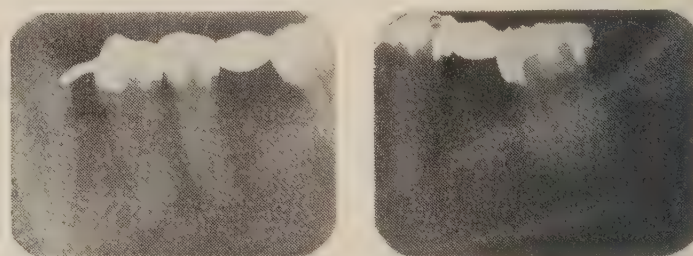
Radiographs taken in October 1968.
